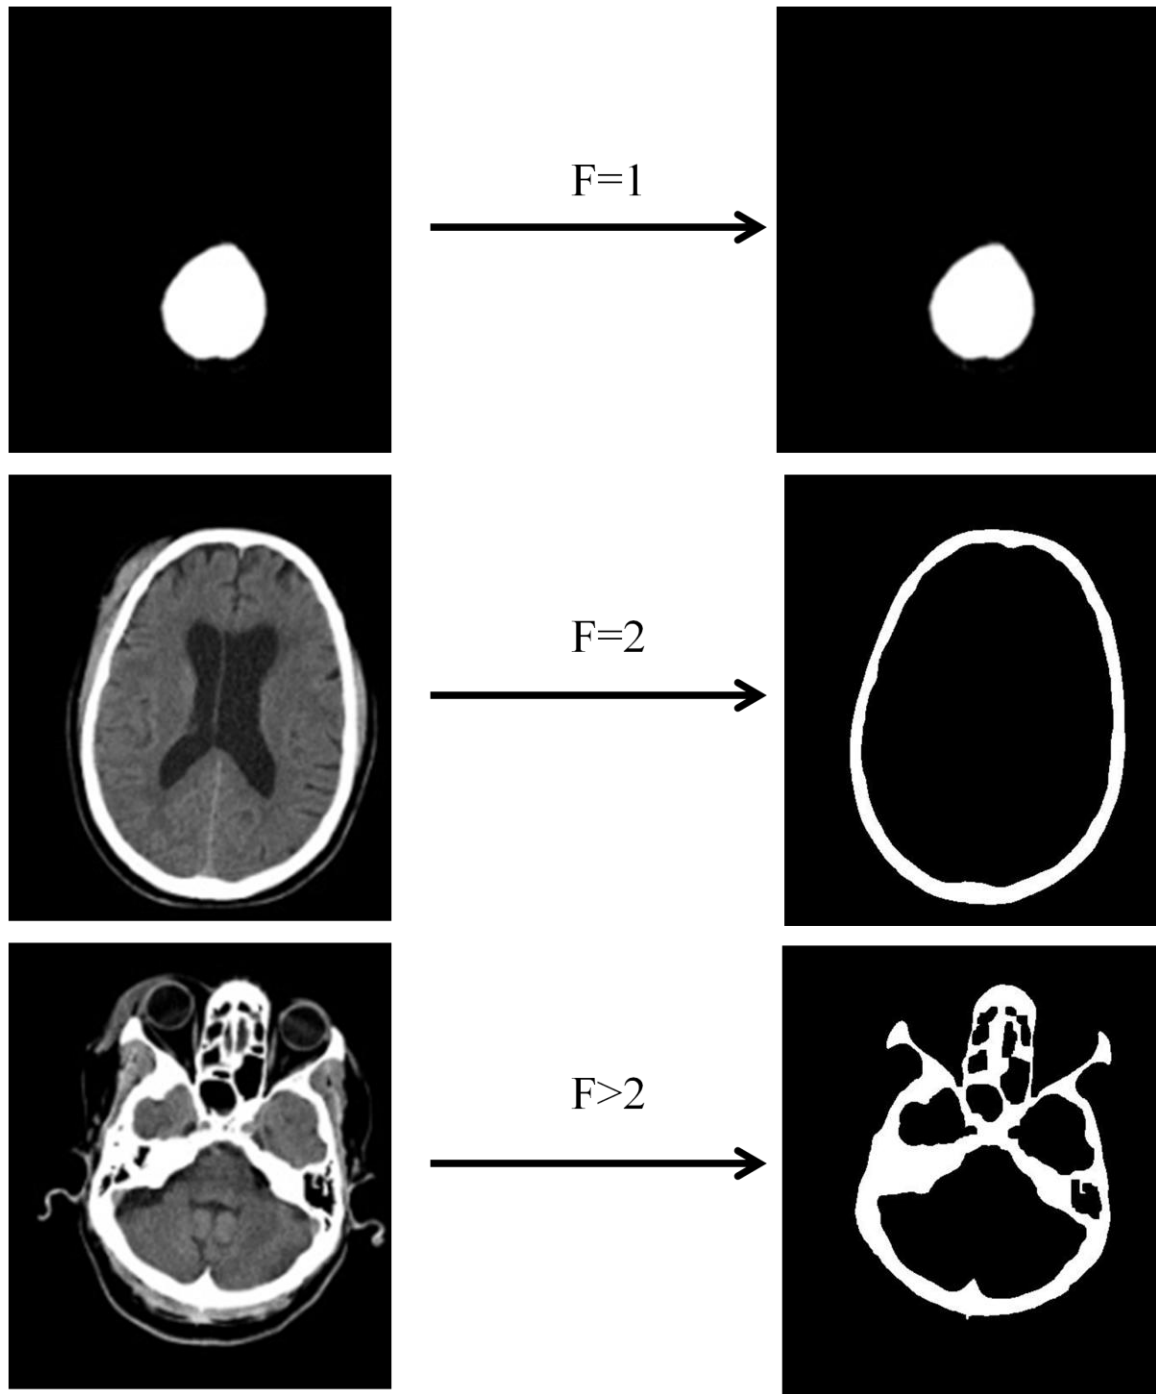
Closed skull inspection. The three left-side images are the raw CT images while the bottom three right-side images show the corresponding detected skulls. The black regions either inside or outside of the detected skull are the above mentioned  $H_k$  with zero matrix. Skull closing level of the three slices equals 1, 2, and more, respectively.
